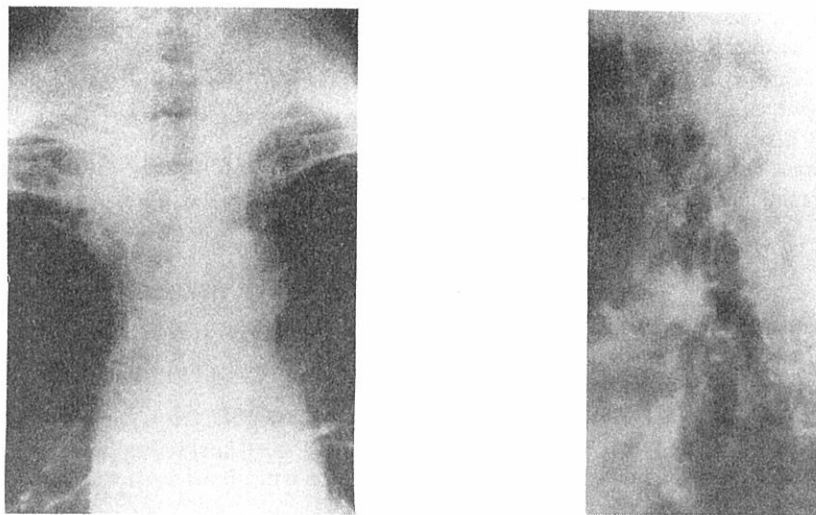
Posteroanterior (A) and lateral (B) chest radiographs show an example of calcification in the main-stem bronchi and more peripherally, but not in the trachea. (MF# [redacted])
